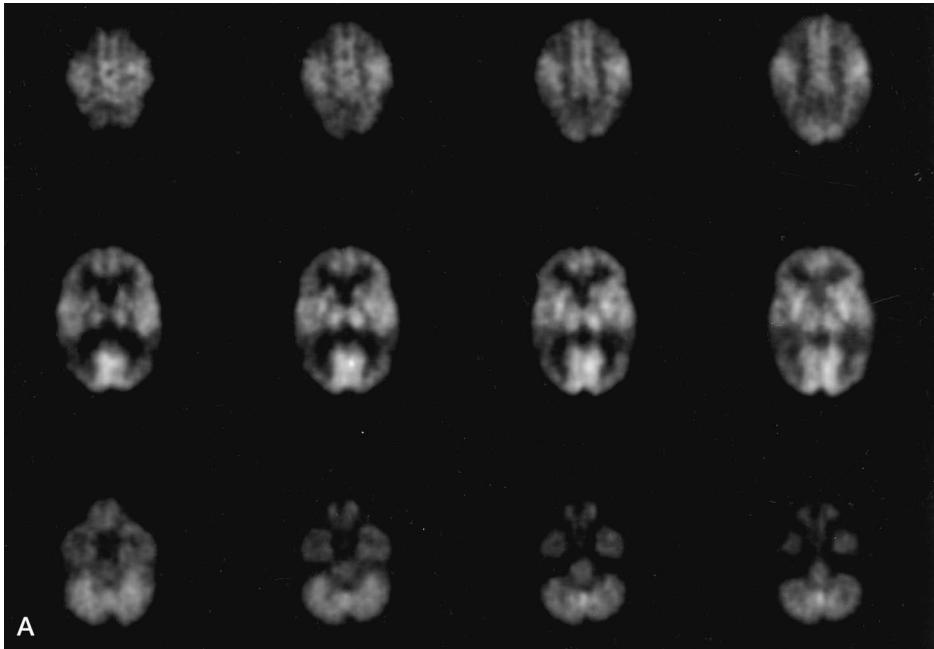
(a) An FDG-PET scan from a patient with severe AD shows severely decreased activity in both temporoparietal regions and both frontal lobes, with relative preservation of the sensorimotor area, visual cortex, subcortical structures, and cerebellum. (b) The corresponding MISRS scoring sheets is included for this patient.
